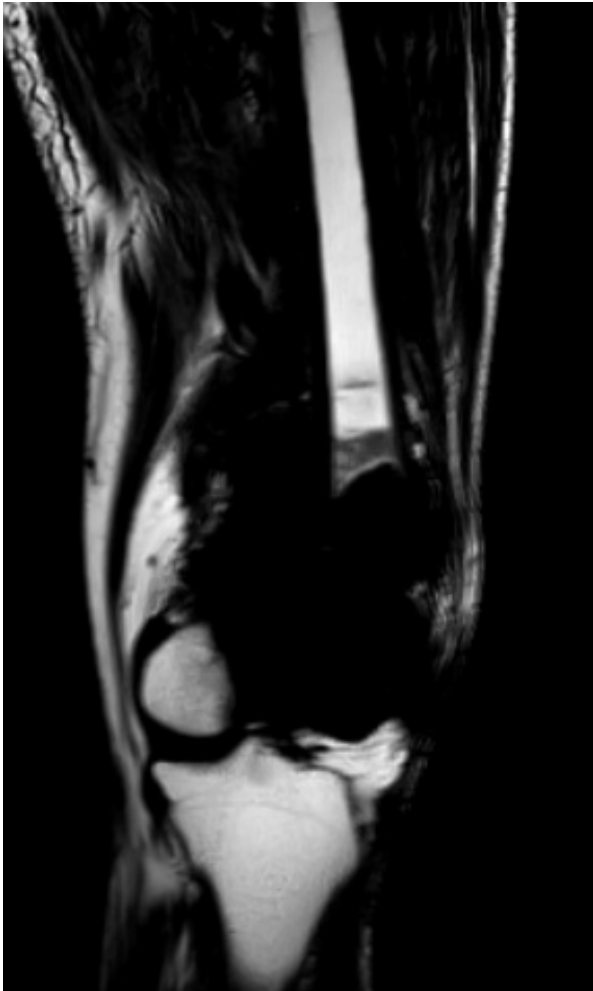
MRI-T2W m DIXON coronal image
